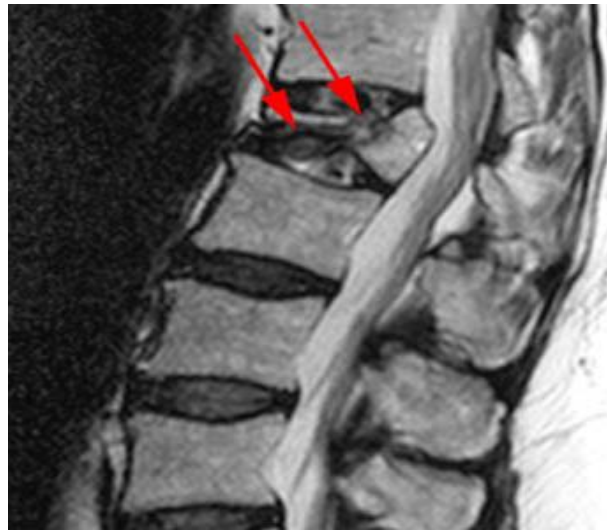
T2-weighted fast spin echo sagittal. Signs of the benign nature of the fracture include preservation of normal T2 marrow signal compared to adjacent segments.
